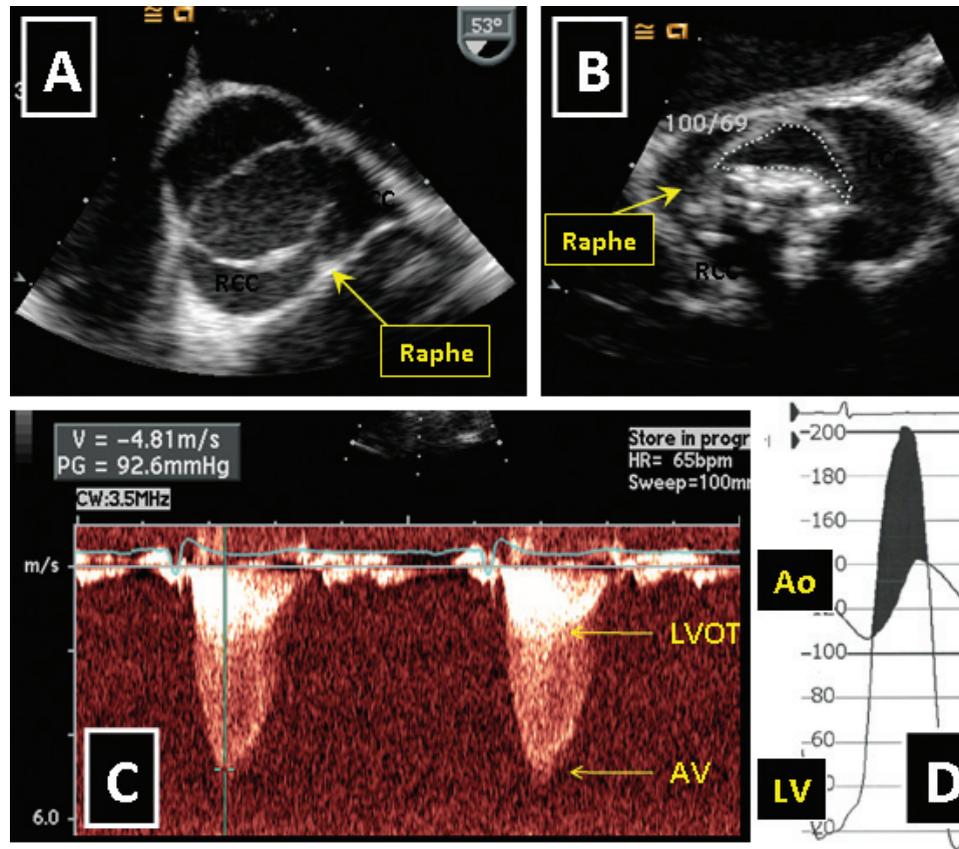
Aortic stenosis. Panel A and Panel B show bicuspid aortic valve on transesophageal echocardiography. In Panel A, the bicuspid valve is not significantly stenotic. This is in contrast to Panel B which shows a severely calcified and markedly stenotic bicuspid aortic valve. Panel C shows continuous wave Doppler recording of blood flow across the aortic valve in systole. Note the wide separation between the normal left ventricular outflow tract (LVOT) velocity and the markedly elevated velocity across the aortic valve (AV). Panel D shows simultaneous pressure recordings from the left ventricle (LV) and the aortic root (Ao). Note the wide separation between the aortic pressure and the markedly elevated LV pressure.
